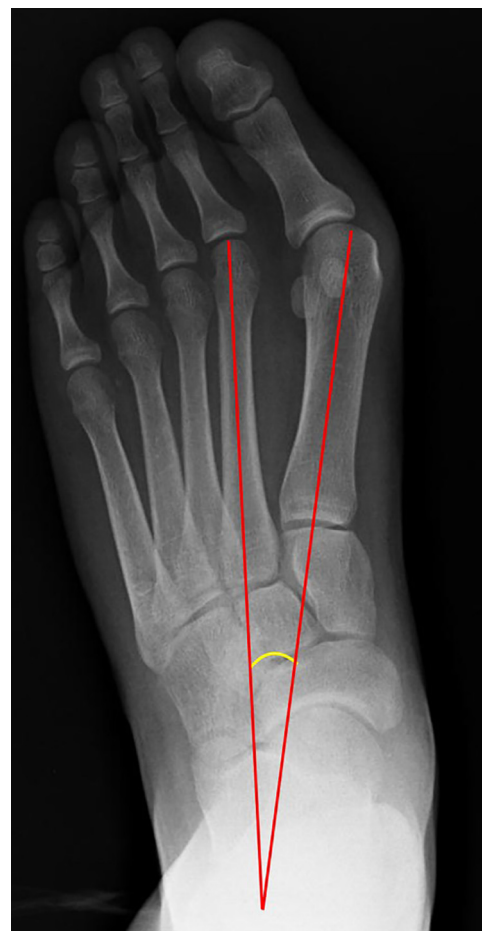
Plain radiograph showing intermetatarsal angle of the hallux.
